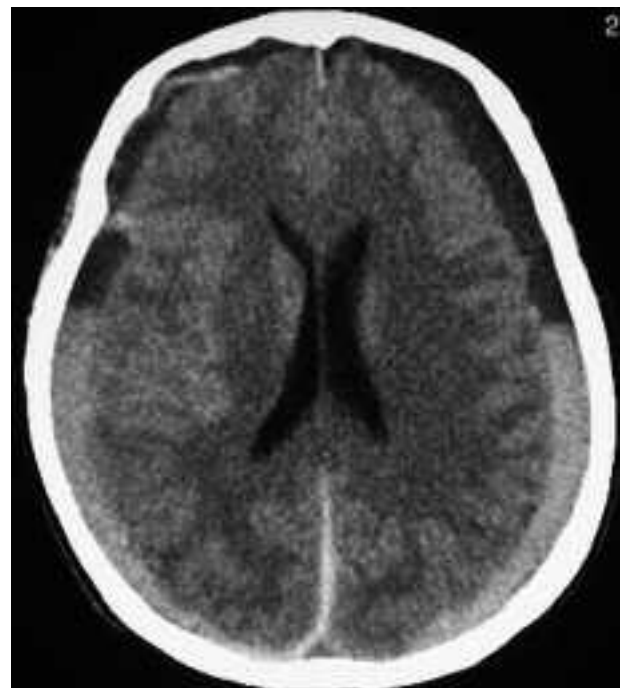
Unifused axial CT scan demonstrating bilateral mixed density subdural collections consistent with acute on chronic subdural hematomas.
